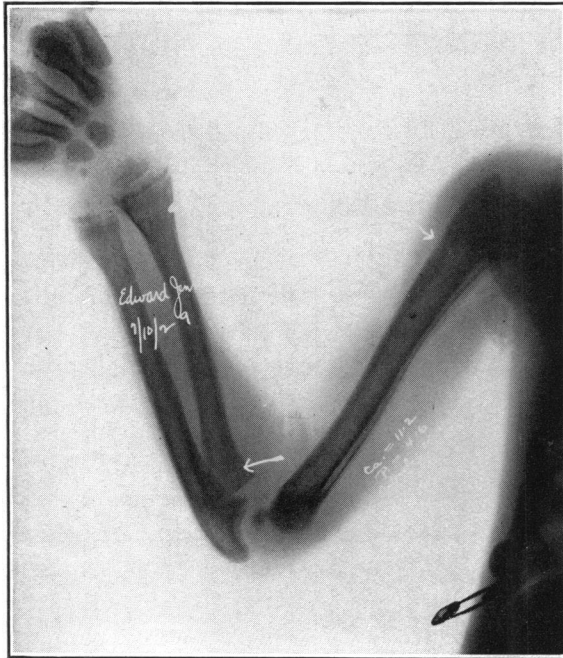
E. J., aged 3 years 4 months. X-ray photograph of arm showing deformity of the humerus acquired from sitting in severe rickets. The part of the humerus indicated by the arrow is the one at which later the bowing developed. Note that at this time no bowing exists and no fracture is present.
